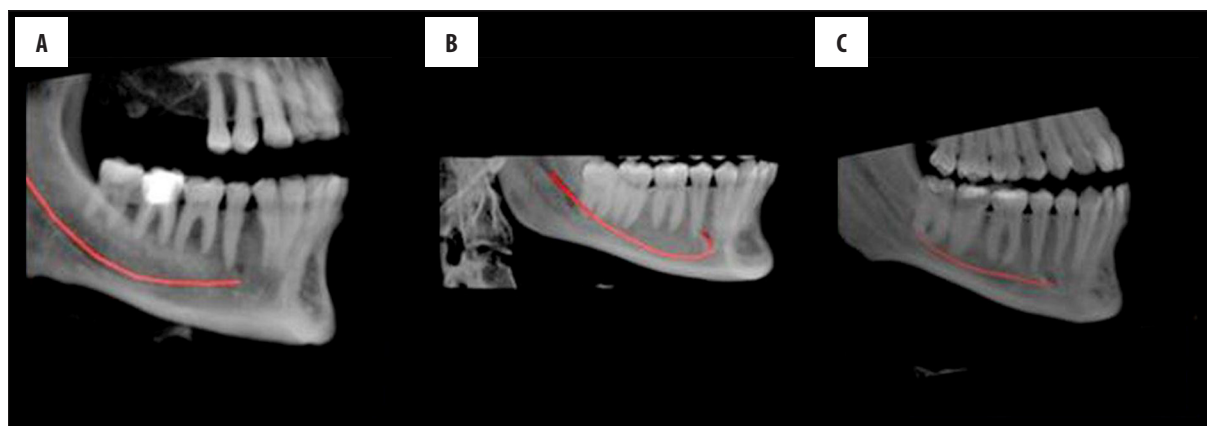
X-ray images of the mandibles showing three types of the mandibular canal: (A) Catenary, a symmetric elliptic arc (B) Progressive descending, a spoon-shape curve similar to a dissymmetry elliptic arc and (C) Straight type, linear pattern.
